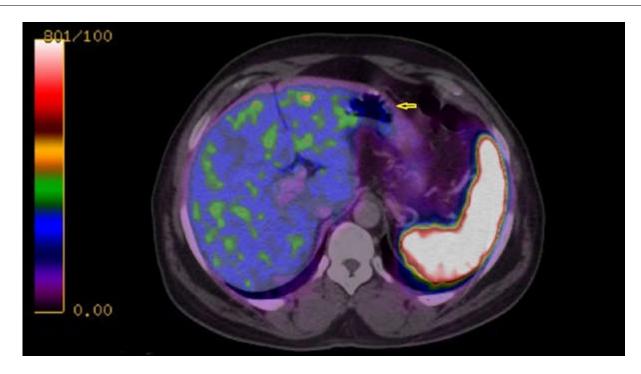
Whole body somatostatin receptor imaging with Ga68- DOTANOC PET CT showing mild increased uptake at the polyp (yellow arrow)
